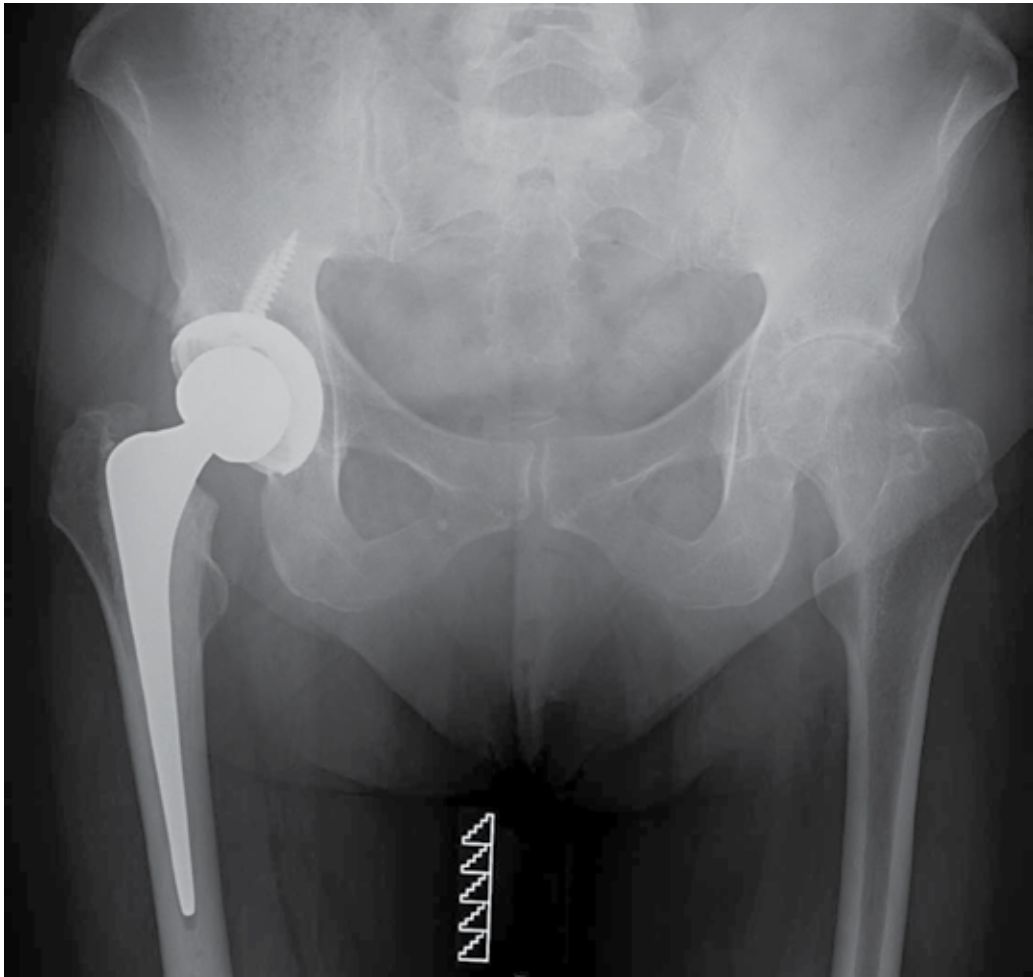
Anteroposterior radiograph of the pelvis showing a right Hybrid (cemented stem/uncemented acetabular cup)THA and osteoarthritic left hip joint.
